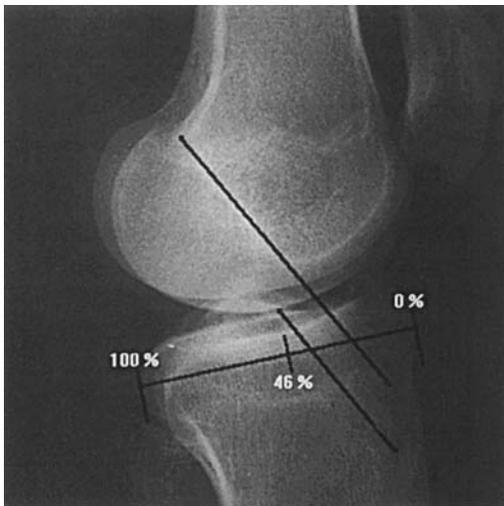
Preoperative hyperextension lateral radiographs with radiographic parameters for graft positioning.
